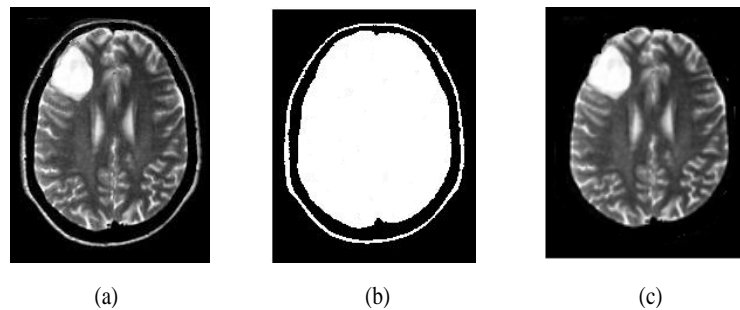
Brain Skull Stripping (a) Original MRI Image (b) Binary Image (c) Skull Stripped MRI Image
